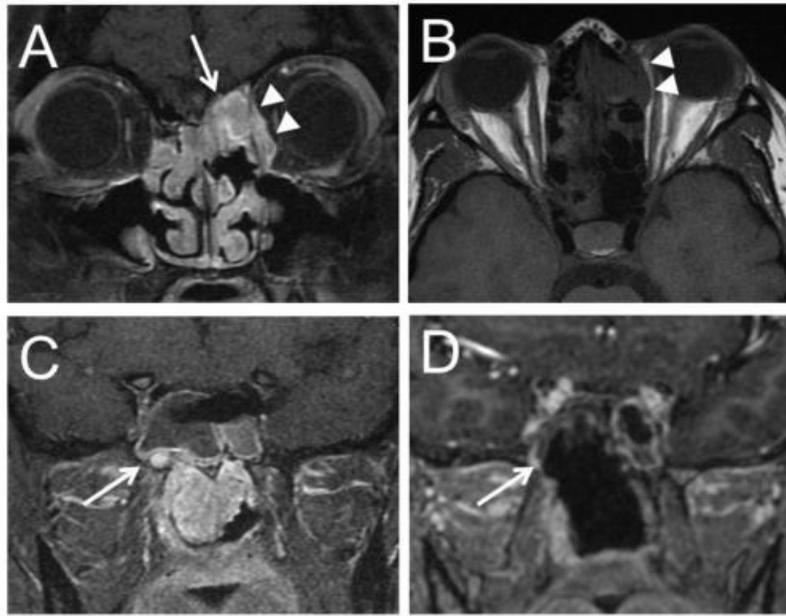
Extrinsic involvement of the skull base in pathology-proven sinonasal immature teratoma, including: invasion of the cribriform plate (A, arrow), left medial periorbita and extraconal fat (A and B, arrowheads) and left vidian nerve (C, arrow). After detailed radiographic analysis, the patient was treated with expanded endoscopic resection including combined left maxillectomy and left medial orbitotomy as well as unroofing of the left vidian canal for tumor debulking (D, arrow).
